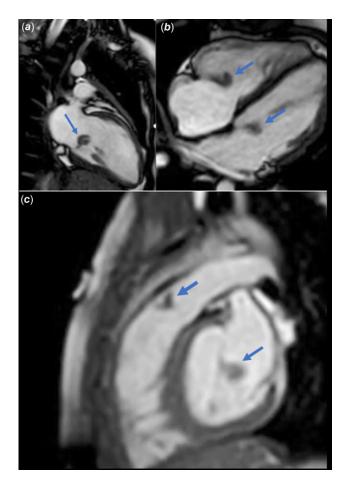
Images of lesions on cardiac MRI. (a) Coronal section modified two-chamber MRI image of the lesion in the mitral valve. (b) Sagittal section four-chamber MRI image of the mitral valve lesion and tricuspid valve lesion. (c) Short-axis MRI image of the lesion in the mitral valve and the lesion of pulmonary valve in the right ventricular outflow tract.
